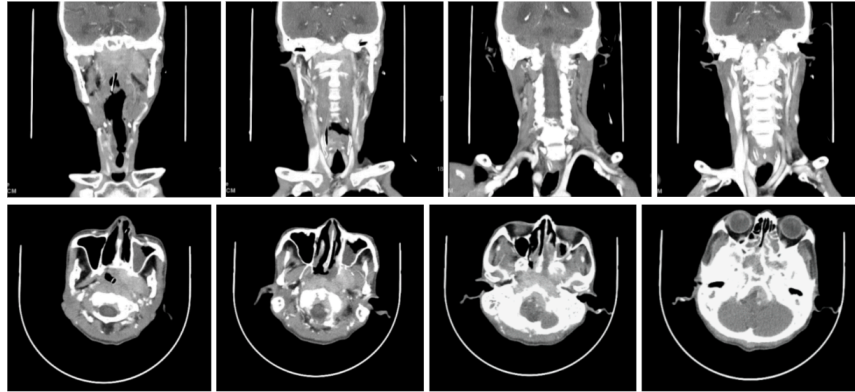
A collage of coronal (top) and axial (bottom) view of nasopharyngeal CT-scan of the patient. Observed on December 2025
